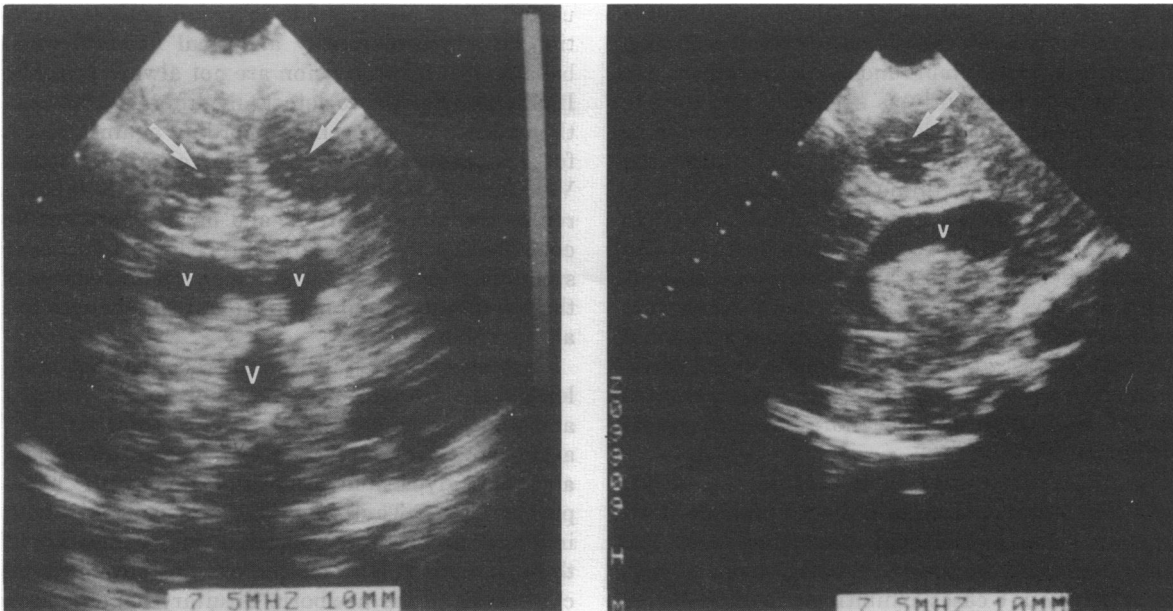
Coronal (left) and parasagittal (right) ultrasound scans of Case 5 with cystic subcortical leucomalacia, showing minimally dilated lateral (v), third (v) ventricles and bilateral subcortical cysts (arrowed). (Reproduced from Archives of Diseases in Childhood<sup>6</sup>, with kind permission)
